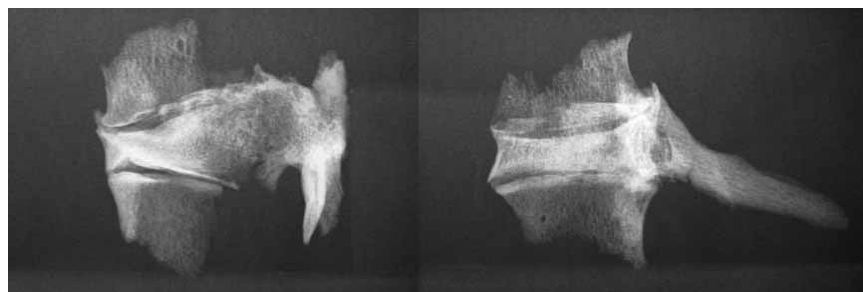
Burial II in grave no. 1. Digital radiography of the three assembled fragments (T11-L1). Note the wedge-shaped deformation of the body of T12 and the absence of osteolysis of the spongy bone.
